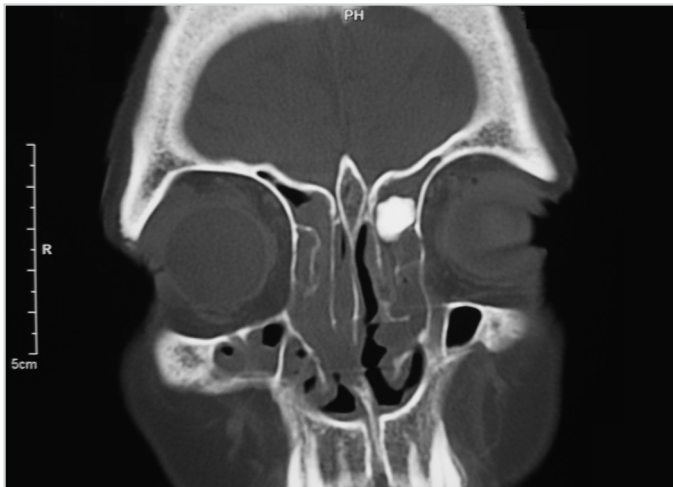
Preoperative PNS CT of the patient who had undergone the endoscopic approach
